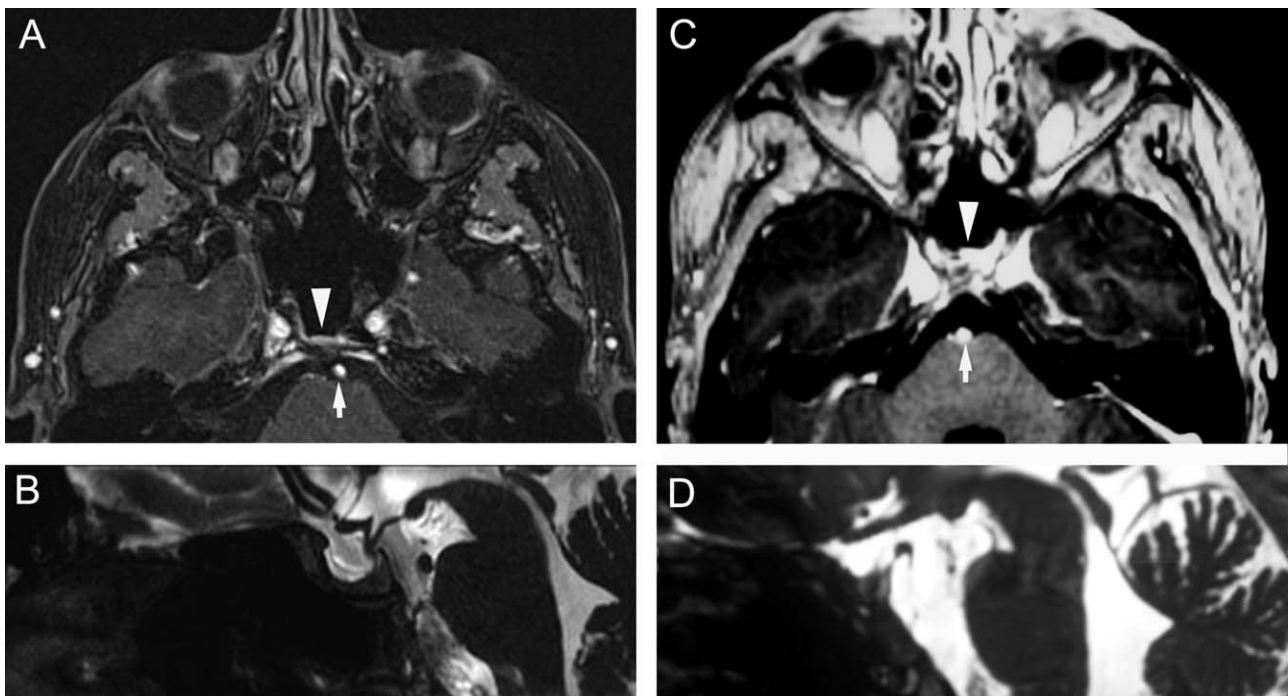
Postoperative MR examination. Case 1: axial, T1-weighted sequence with fat saturation and gadolinium (A) and sagittal, T2-weighted sequence (B). Case 2: axial, T1-weighted sequence with gadolinium (C) and sagittal, T2-weighted sequence (D). In both cases, the NSF appears well vascularized and properly placed within the infrasellar recess (white arrowhead). The white arrow points at the basilar artery.
